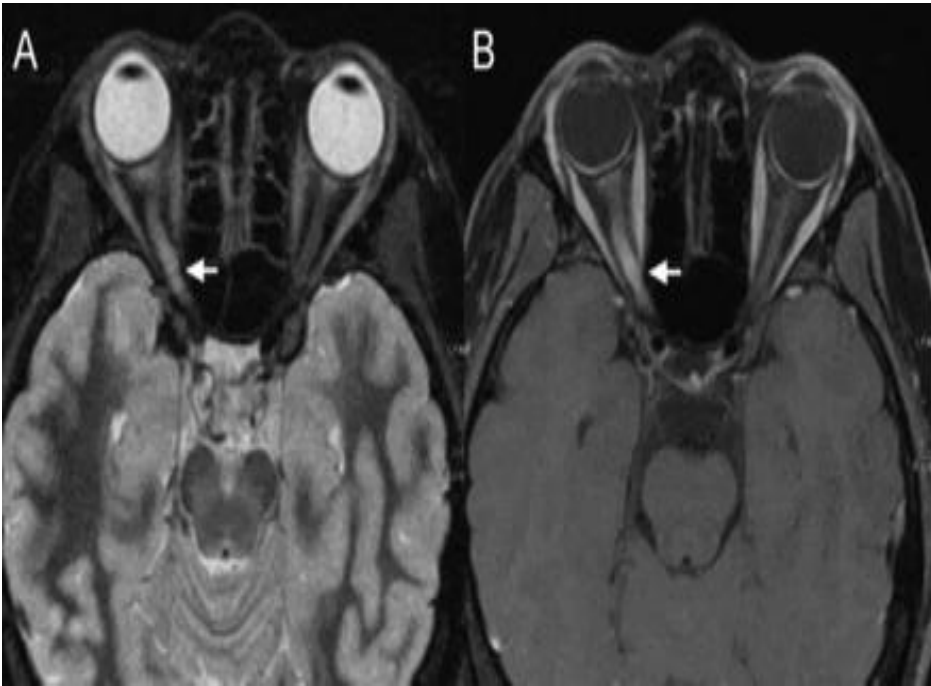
MRI short tau inversion recovery, axial, high-intensity edematous lesion in the right optic nerve (A) with contrast enhancement (B) in a patient with the first episode of optic neuritis and aquaporin-4 (AQP4) antibody positivity. Adapted from [82](#).
